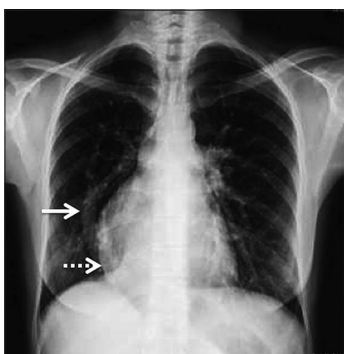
Chest X-ray frontal view showing a curved radiopaque shadow coursing inferomedially along the right cardiac border (arrow). In addition, there is abnormal right cardiac border, shifted to the right side with increased convexity (dashed arrow) and small right lung hilum
